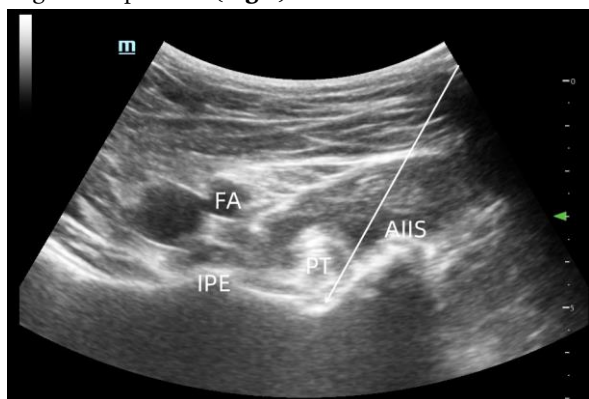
Images of ultrasound-guided pericapsular nerve group (PENG) block via a lateromedial approach. The white arrow indicates the trajectory of the needle. AIIS, anterior inferior iliac spine; FA, femoral artery; IPE, iliopubic eminence; PT, psaos tendon.
